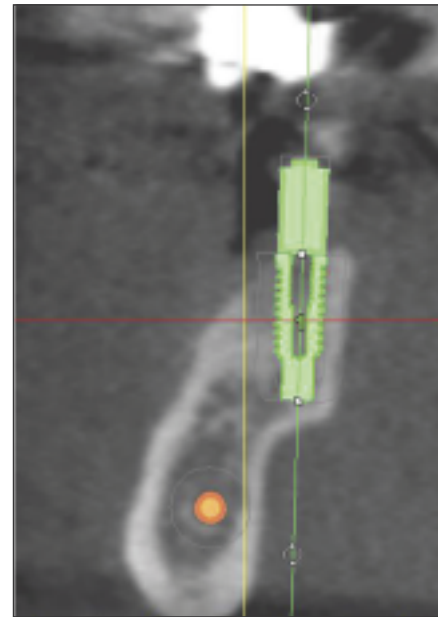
Cross-sectional view of CBCT scan; showing how angulations, implant length, and anatomy can be visualized.
